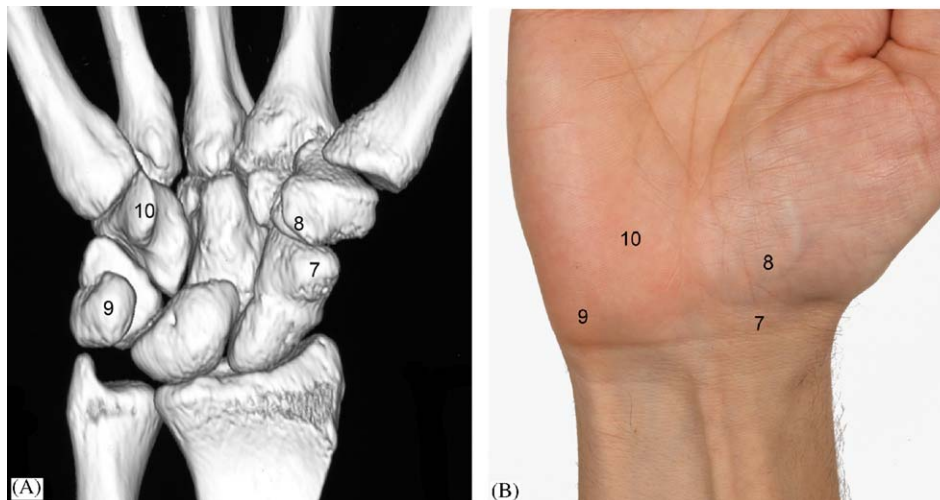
Palmar view of the carpus and wrist as 3D CT reconstruction (A) and clinical photograph (B). Landmarks in both figures are—(7) tubercle of the scaphoid, (8) tubercle of trapezium, (9) pisiform, (10) hook of hamate.
